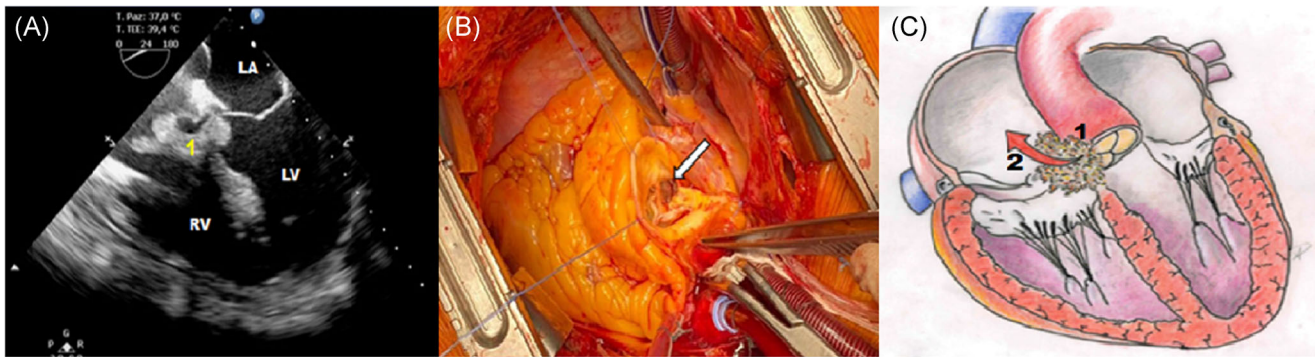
Preoperative presentation. A, Preoperative transesophageal echocardiogram; 1: abscess. LA, left atrium; LV, left ventricle; RV, right Ventricle. B, Intraoperative view; The arrow: through the aortic valve, it is possible to see the septum. C, 1: abscess and vegetation across interatrial and interventricular septum, 2: shunt from the aorta to right heart cavities
